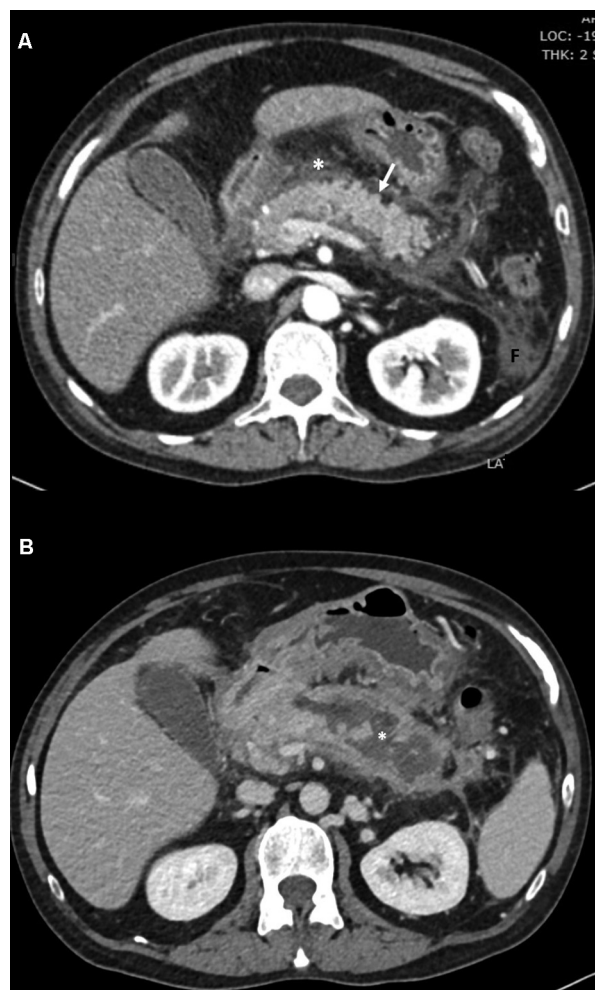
Computed tomography (CT) in a 55/M with alcohol-related recurrent acute pancreatitis (RAP), due to a continuous history of alcohol abuse. (A) Noncontrast-enhanced CT (NECT) in axial plane shows the pancreas of normal bulk and enhancement but has peripancreatic fat stranding (white arrow) suggesting mild acute pancreatitis. (B) Same patient reported to the emergency room (ER) after 6 years due to acute pancreatitis. Contrast-enhanced CT (CECT) in axial plane shows necrotic regions with acute fluid collections (white star).
